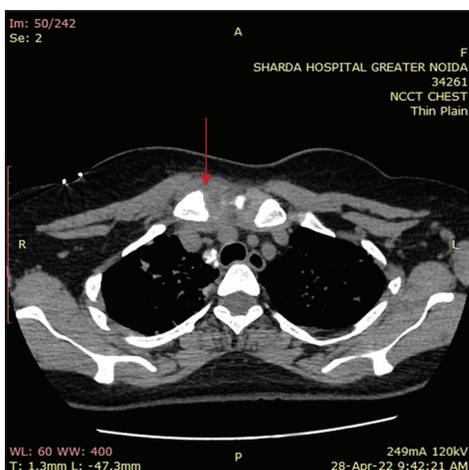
CT scan mediastinal window (axial image) shows ill-defined soft tissue along the sternoclavicular joint on the right side (marked by red arrow). A small right paratracheal calcified lymph node is also seen
